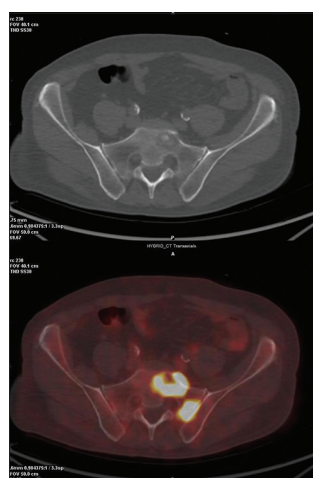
Positron emission tomography–computed tomography images showing sacral bone metastasis, with high-level glucose uptake
